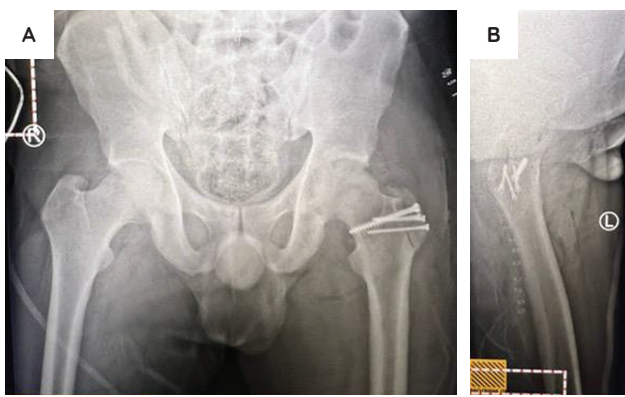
Post-operative radiographs—anteroposterior (A) and left lateral hip view (B)—taken on the day of surgery, 8 weeks after the initial injury.
